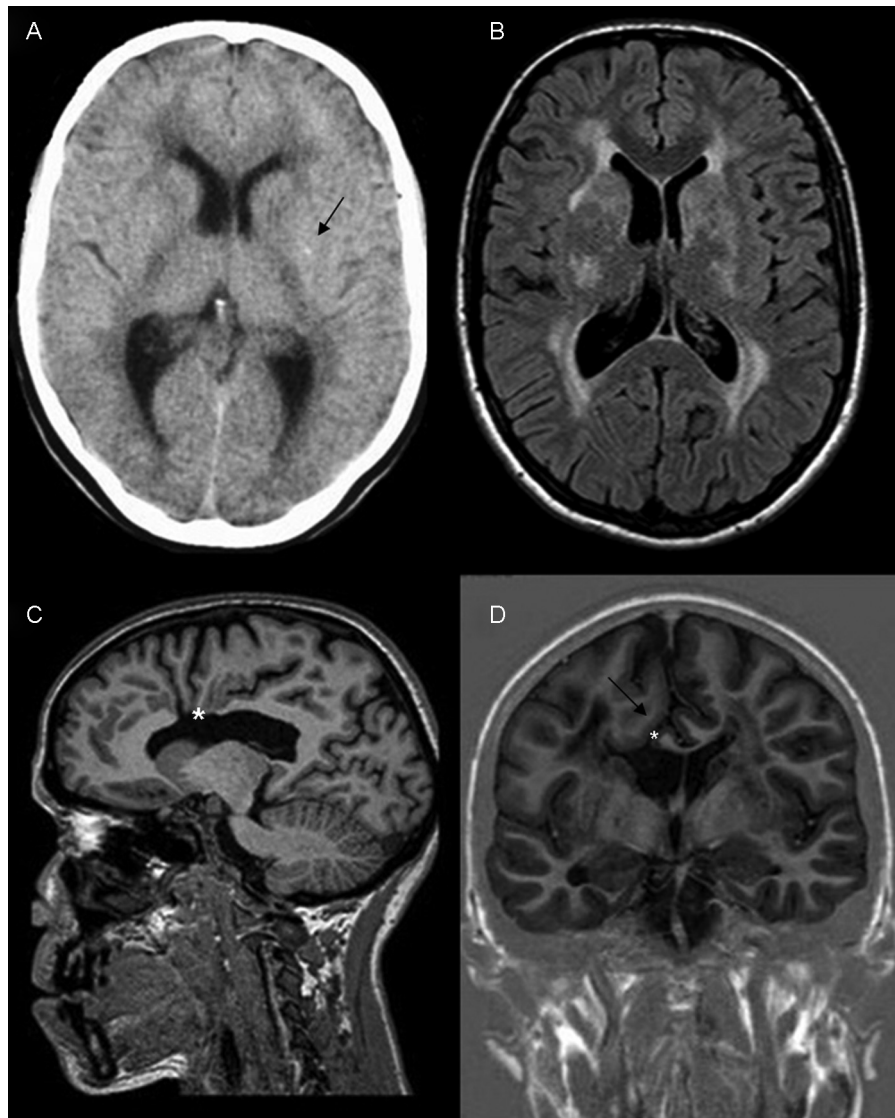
CT and MRI of patient 1. (A) Axial CT brain image showing a punctate calcification in the left putamen (arrow). (B) Axial T2-weighted MRI scan showing periventricular, deep white matter, and basal ganglia high signal abnormalities. (C) Sagittal T1-weighted magnetic resonance three-dimensional fast-field echo image shows a defect of the right central portion of the callosal trunk (asterisk). (D) Coronal T2-weighted inversion recovery MRI scan: a narrow right mesial frontal schizencephalic cleft lined by dysplastic cortex allows apparent direct communication between the right lateral ventricle and the interhemispheric fissure (arrow). A right central callosal defect is confirmed in the coronal view as well (asterisk). CT, computed tomography; MRI, magnetic resonance imaging.
